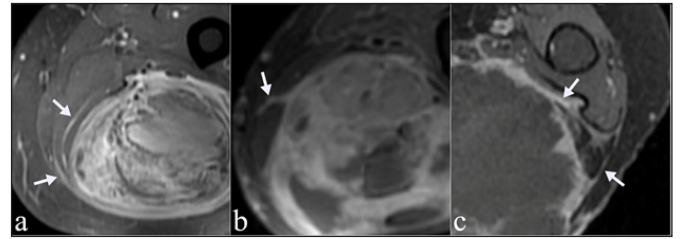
The tail sign is a signal extending curvilinearly along a certain plane with the same enhancement as the main mass in contrast-enhanced series. a. In the thigh MRI of a 41-year-old male patient, pleomorphic sarcoma and tail-sign were shown with an arrow. b. In the thigh MRI of a 62-year-old male patient, myxofibrosarcoma and tail-sign were shown with an arrow. c. Right arm MRI of a 85-year-old female patient, leiomyosarcoma and tail-sign were shown with an arrow.
